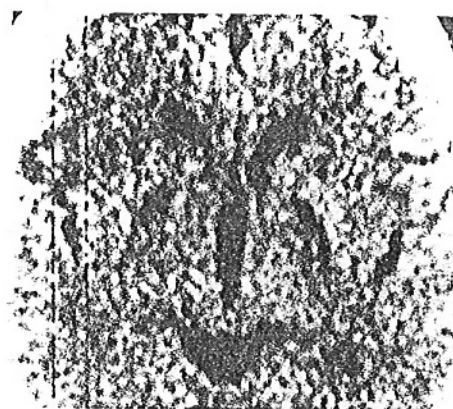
Case 1. CT scan at basal ganglia level, in OM plane, showing small lesions in caudate and putamen and large bilateral lesions in the internal part of lenticular nuclei. (Left hemisphere is presented on the right side of the picture.)
